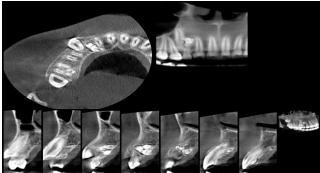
CBCT sagittal, axial and coronal view.
